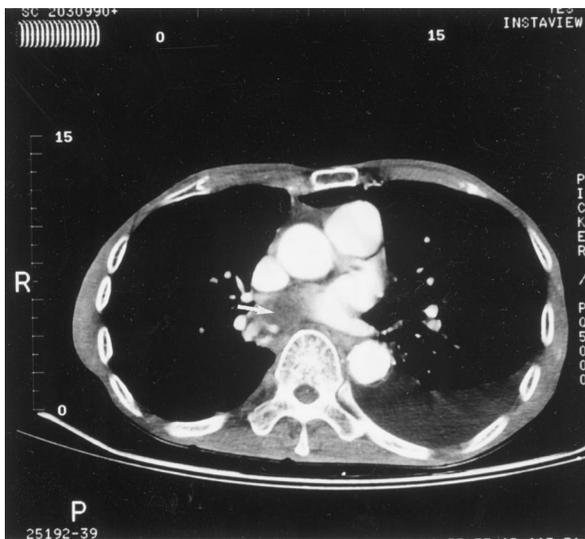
Spiral CT scan of the thorax which shows a filling defect consistent with PE in the right pulmonary artery (white arrow).
